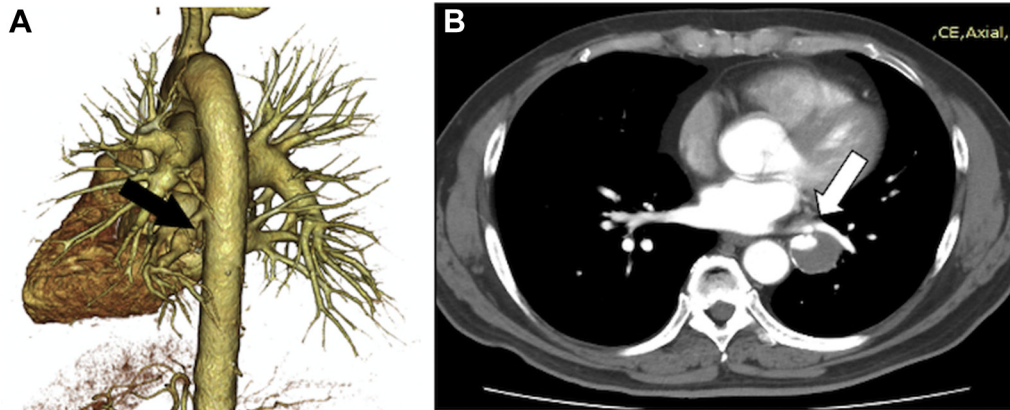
Preoperative three-dimensional computed tomography (CT) reveals that an aberrant feeding artery is originated from the descending thoracic aorta (arrow) (A) and an aberrant aneurysm (B).
